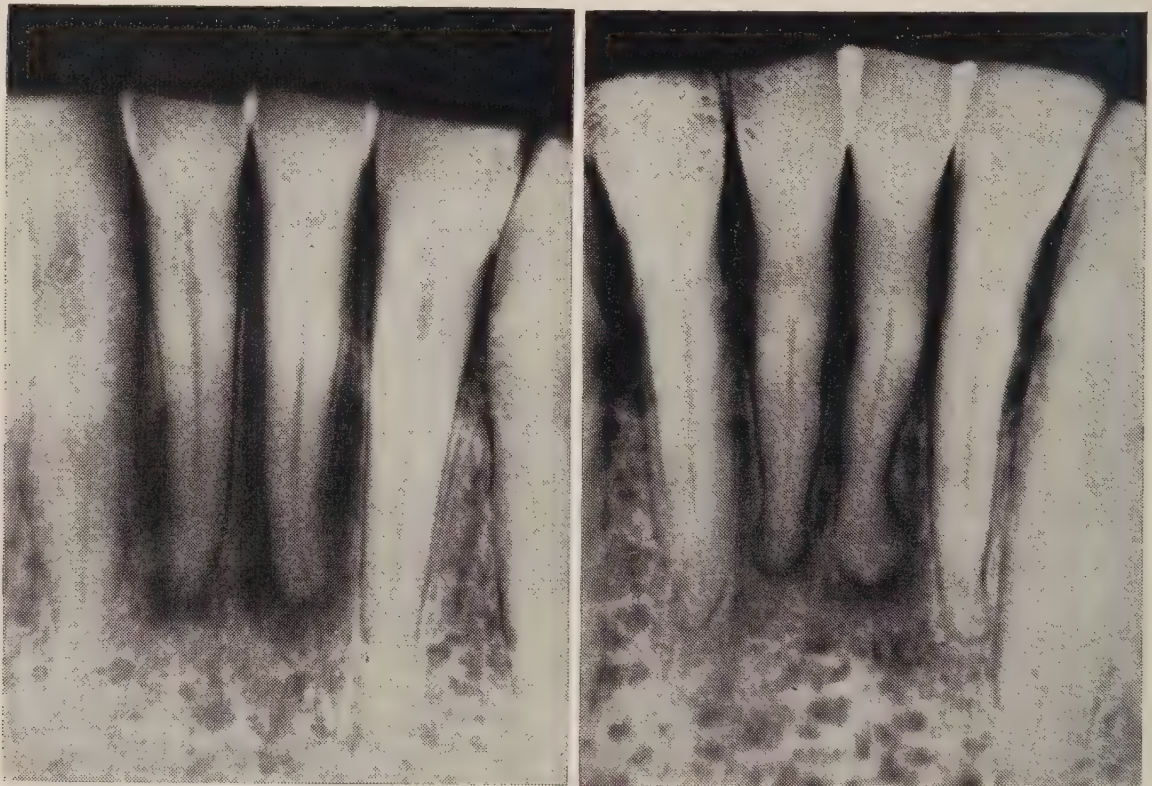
Two examples of the radiographic appearance of early periapical fibro-osteocementoma of the lower incisor region.
